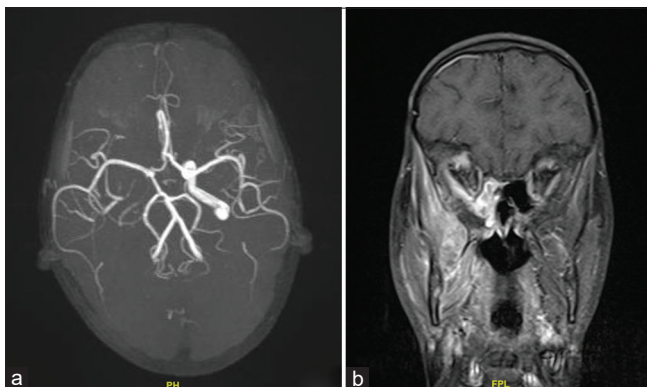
(a) Magnetic resonance imaging showing internal carotid artery thrombosis. (b) Magnetic resonance imaging showing cavernous sinus thrombosis and abscess in the temporal region
